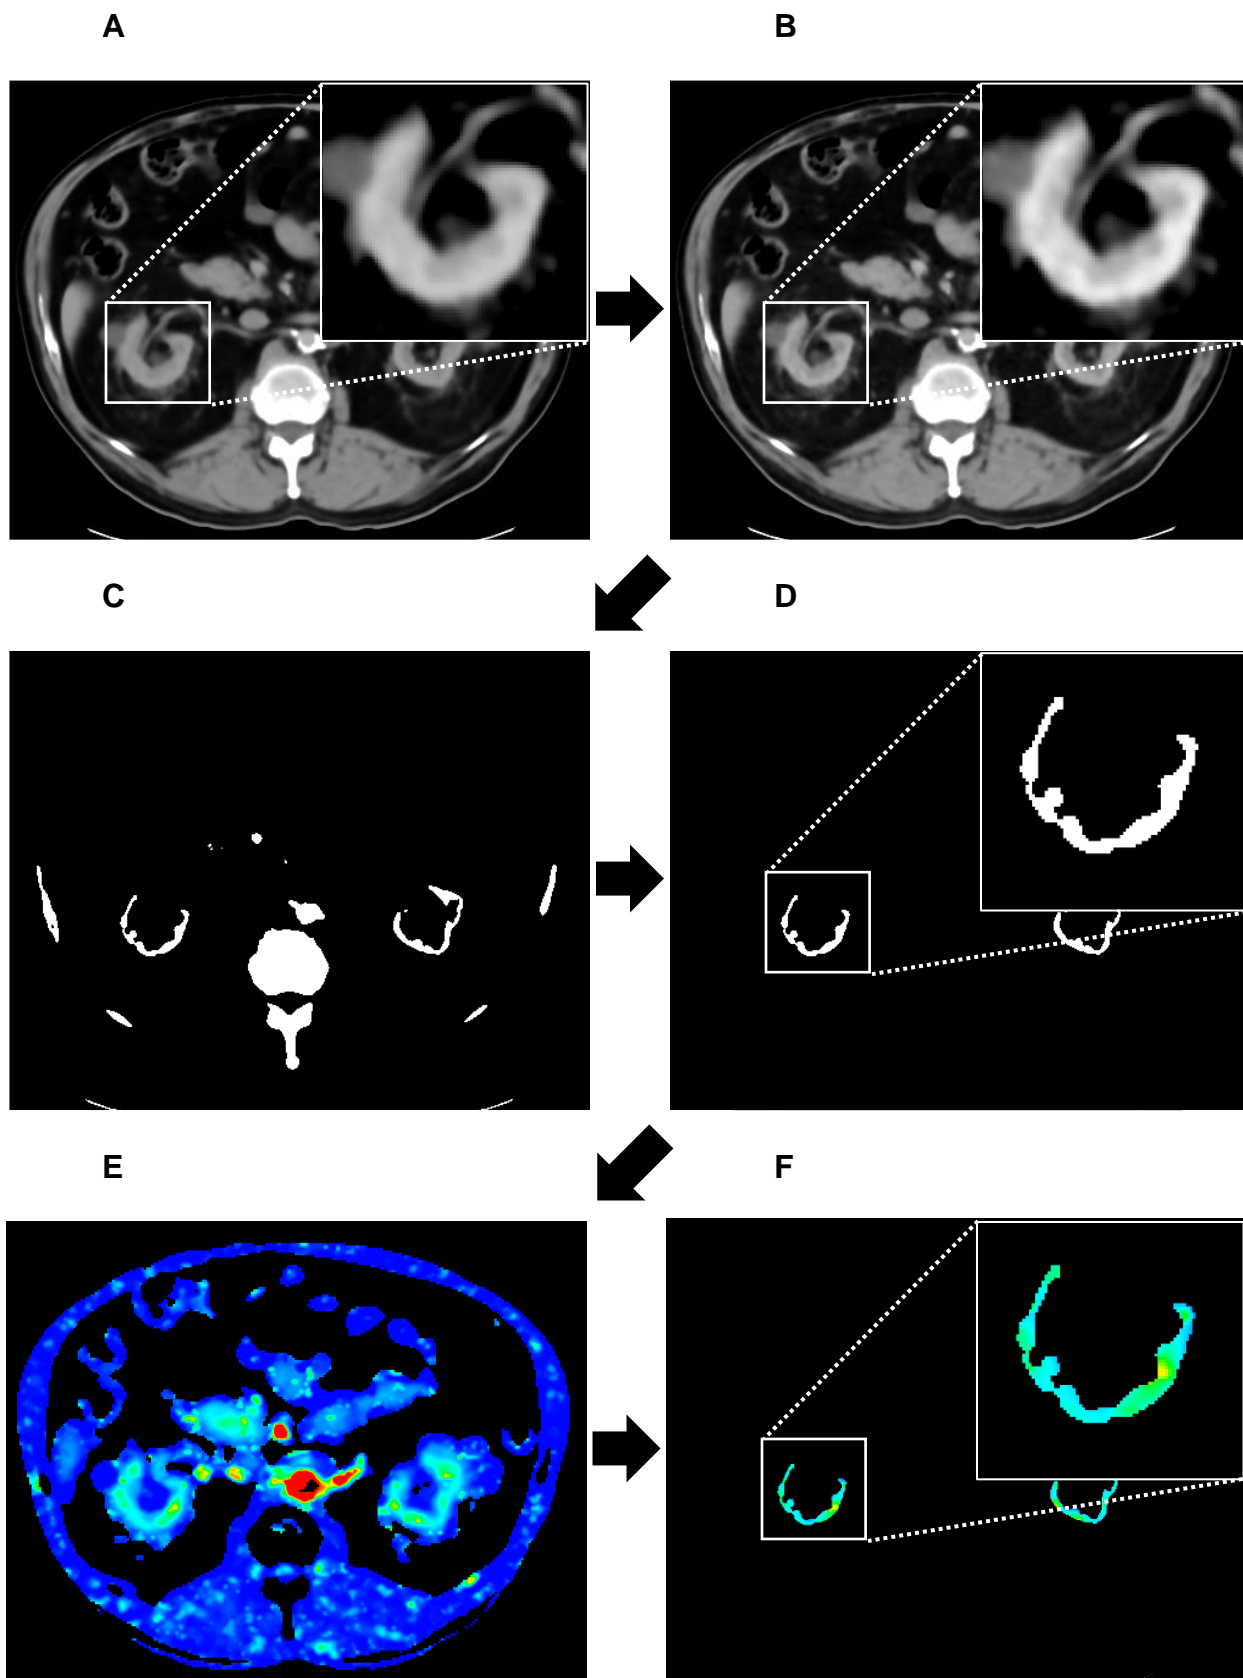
Image processing steps for CTP-based GFR measurement. (A) Average of entire dynamic series CT images with poor corticomedullary differentiation. (B) Summation of cortical phase timepoints (i.e., second quarter of dynamic series CT images) only, demonstrating a minor yet noticeable improvement in corticomedullary differentiation. (C) Application of dynamic threshold (anatomically matching the segmented cortical region to the contrast-enhanced cortex of the summed image as closely as possible), (D) allowing for creation of cortical region masks. (E) Cortical region masks were superimposed onto the perfusion and permeability-surface area product map, (F) yielding values that were used to calculate GFR (as described in section 4.2.3).
